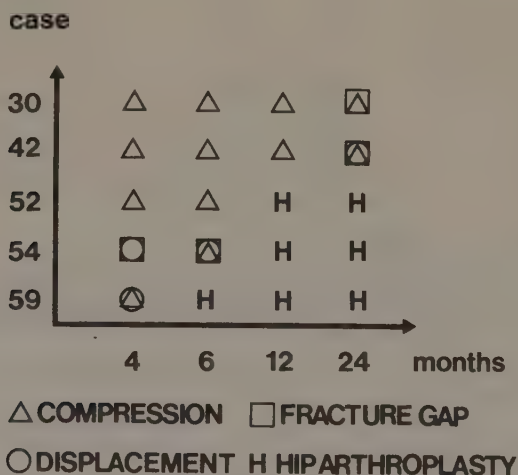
Radiographic changes in the fracture area of five femoral neck fractures with pseudarthrosis/non-union
